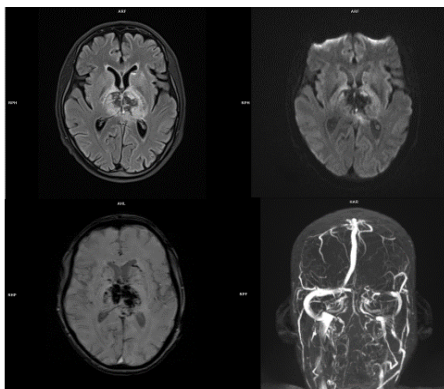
Venous infarct. Axial section of the brain shows diffusion restriction in bilateral thalami on DWI (a) and ADC (b) with foci of susceptibility noted within on SWI images (c). MR venography (d) shows filling defect in left transverse sinus
